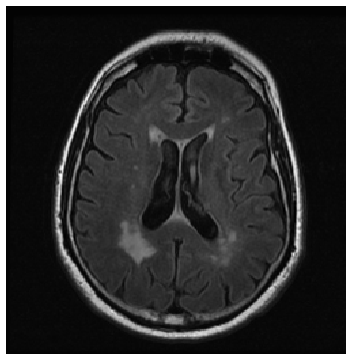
FLAIR-MRI image is able to show lesions as bright hyper-intense regions of the brain
